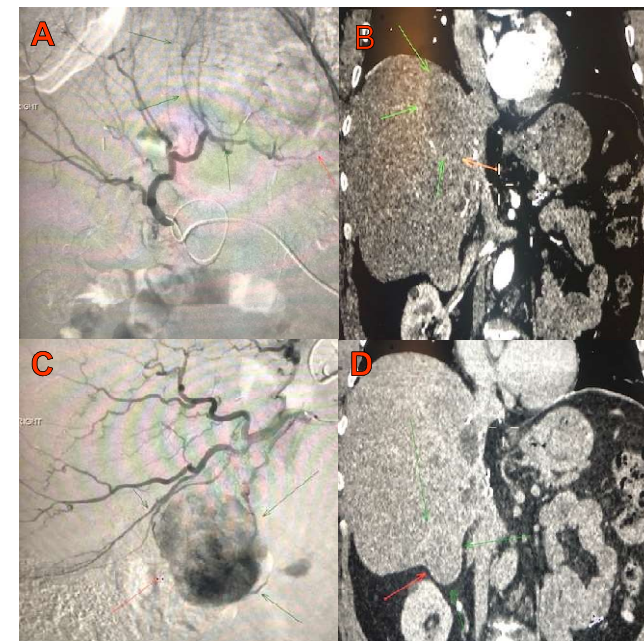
Digital subtracted contrast angiogram and coronal CT abdomen images prior to locoregional therapy demonstrating metastases (arrows) within segment VII (Picture A and B) and segment VI (Picture C and D).]
